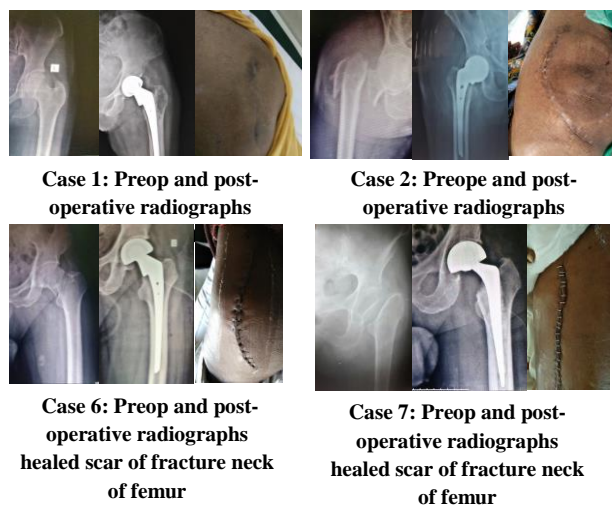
Pre-op and postoperative radiographs of femur fractures.
